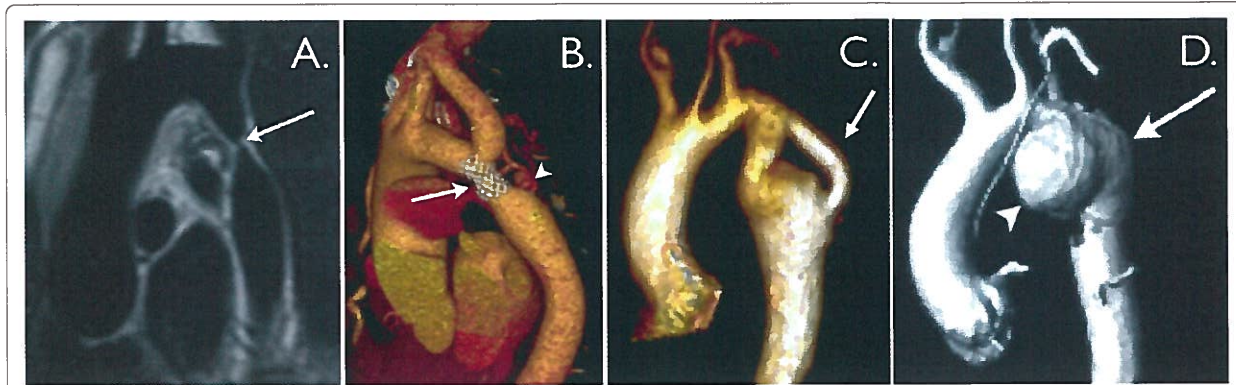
Aortic coarctation. A. 'Black-blood' oblique sagittal view showing discrete, tight coarctation at the aortic isthmus (arrow). B. 3D, contrast-enhanced CT angiogram showing mildly narrowed bare metal stent (arrow) that partially overlies the left subclavian artery origin. The arrowhead shows a subtle pseudo-aneurysm at the distal end of the stent. C. 3D, contrast-enhanced MR angiogram showing aortic arch hypoplasia and coarctation with a 'jump' by-pass graft posteriorly (arrow). D. 3D, contrast-enhanced MR angiogram showing large pseudo-aneurysm (arrowhead) after previous patch angioplasty repair. The true lumen is shown posteriorly (arrow).
